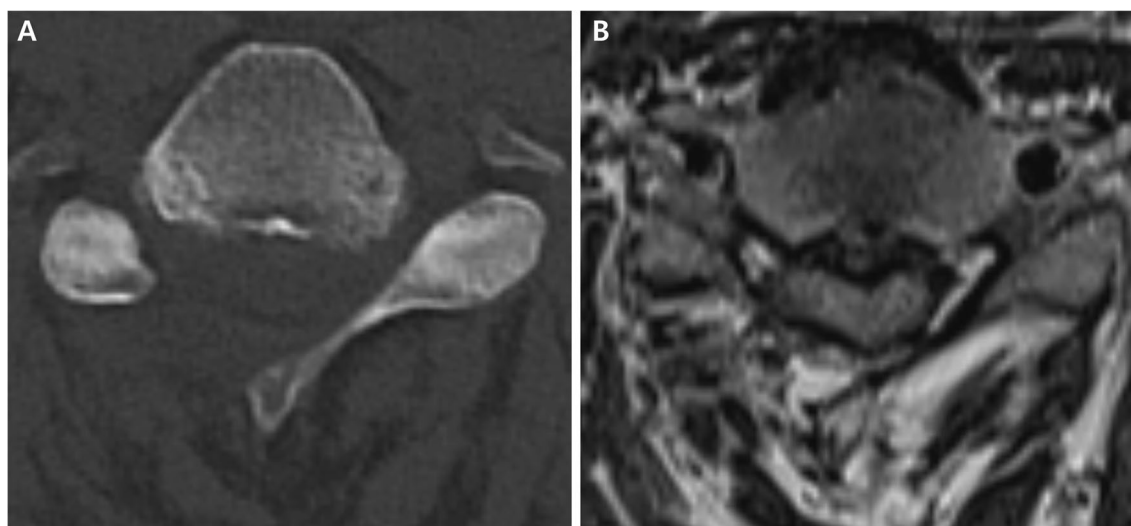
Post-operative images of Case 2. A: Axial plane of CT scan, confirming the removal of nodular masses bilaterally. B: Axial plane of MRI scan, showing sufficient cord decompression
